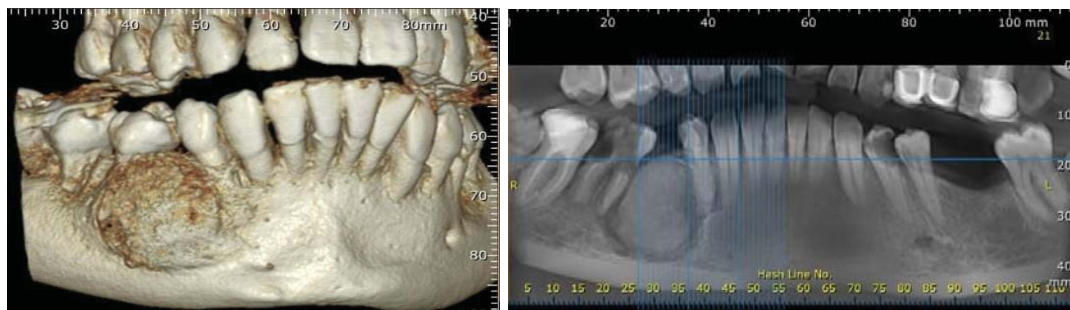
CBCT sections region 44,46 showing a well-defined oval shaped radiopacity surrounded by a thin radiolucent rim
